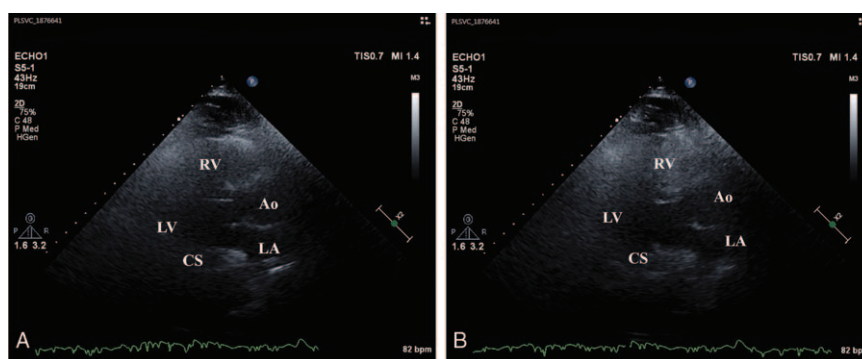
Following injection of contrast saline, echocardiography showed immediate opacification of the coronary sinus (A) followed by subsequent opacification of the right ventricle (B). Ao=aorta, CS=coronary sinus, LA=left atrium, LV=left ventricle, RV=right ventricle.
